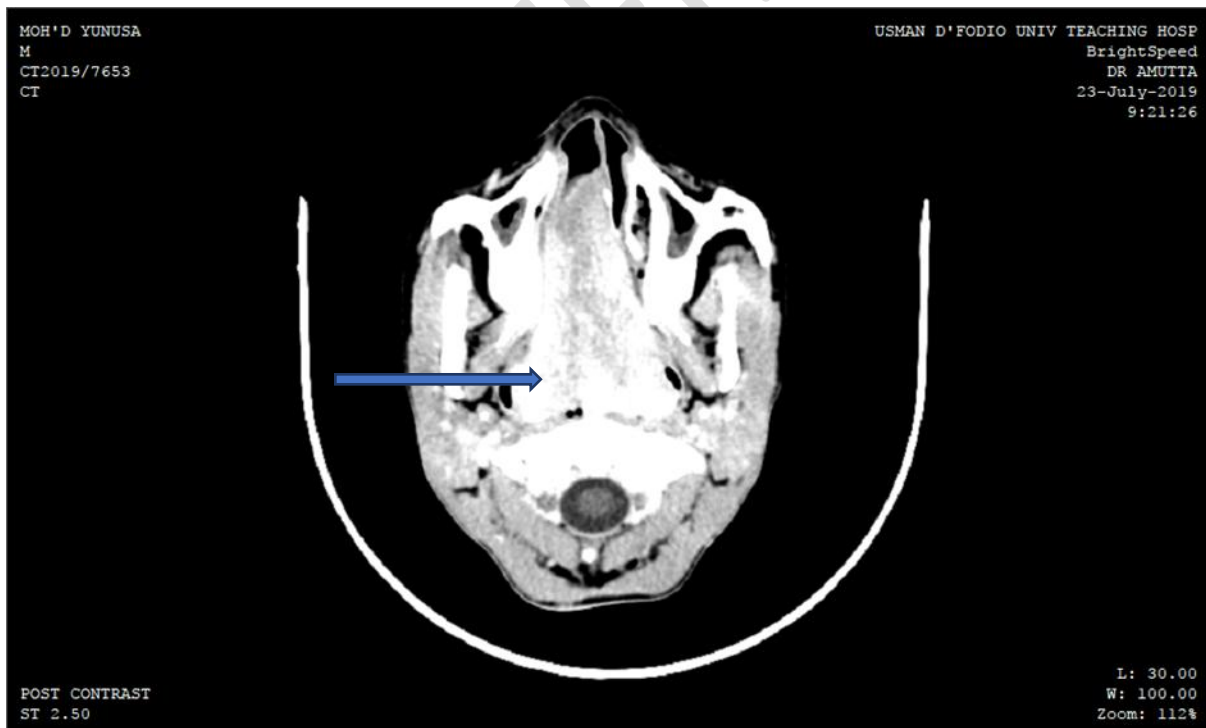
Post-contrast CT scan of the paranasal sinuses showed a contrast-enhanced mass (blue arrow) in the nasopharynx and right nasal cavity.
